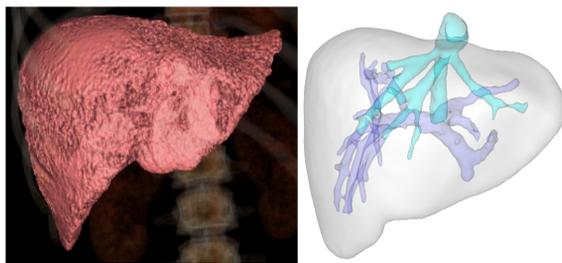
3D rendered and segmented liver CT data
